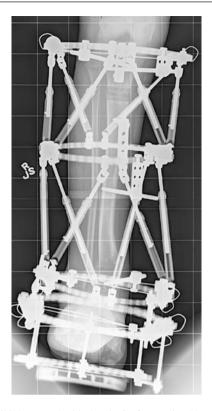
AP tibial X-ray: double-level TSF for proximal lengthening and distal varus correction
